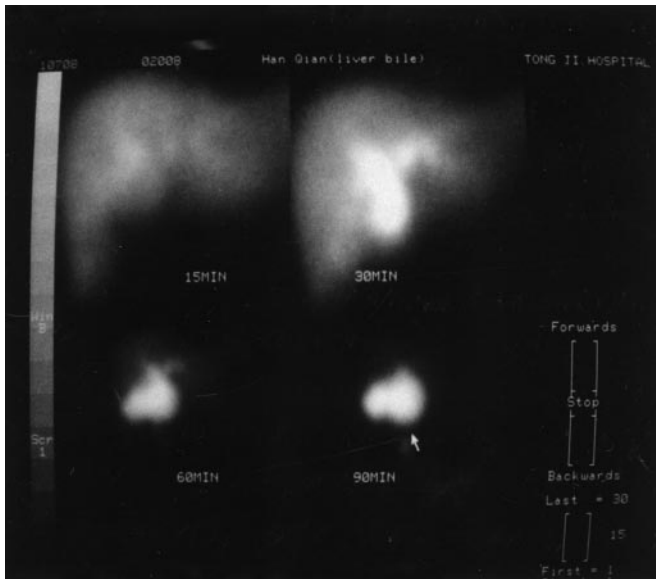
Preoperative SPECT scan showing large developing cyst
